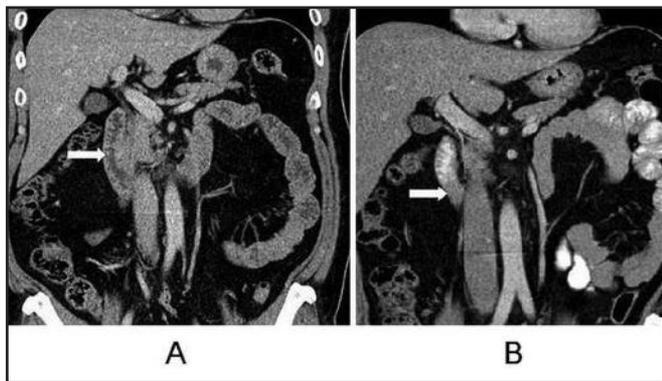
Selected coronal CT images of a 50-year-old male patient with water (A) and gastrografin (B) as OC showing slightly better delineation of the duodenal wall with water as neutral OC. In this case, the mucosal folds were deemed better seen with water as OC compared to gastrografin (arrows).
